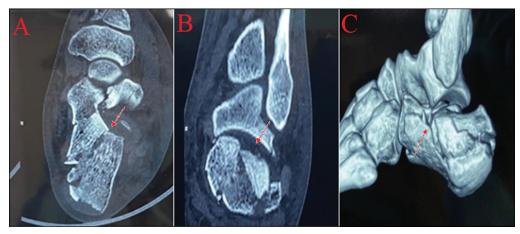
CT-Scans of heel with three-dimension reconstruction depicting detailed fracture morphology
